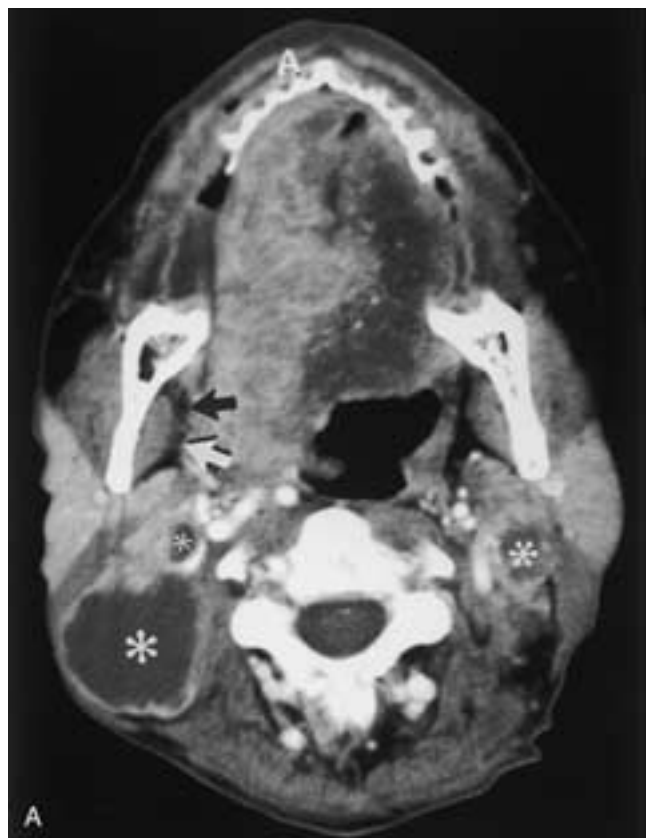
Squamous cell carcinoma. A and B, Axial contrast-enhanced CT scans demonstrate a large lateral oral tongue tumor that extends to involve the entire right oral tongue and extends posteriorly to the tongue base/oropharynx. The right parapharyngeal space fat is different in density from that on the left, with a "dirty," stranded appearance most likely representing tumor infiltration (*arrows* in A). Tumor extension across the midline is obvious in A. Large, malignant-appearing, necrotic lymph nodes are present bilaterally (*asterisks*). Obstruction of Wharton's duct is suggested by identification of intraglandular duct dilatation in the right submandibular gland (*arrows* in B).
